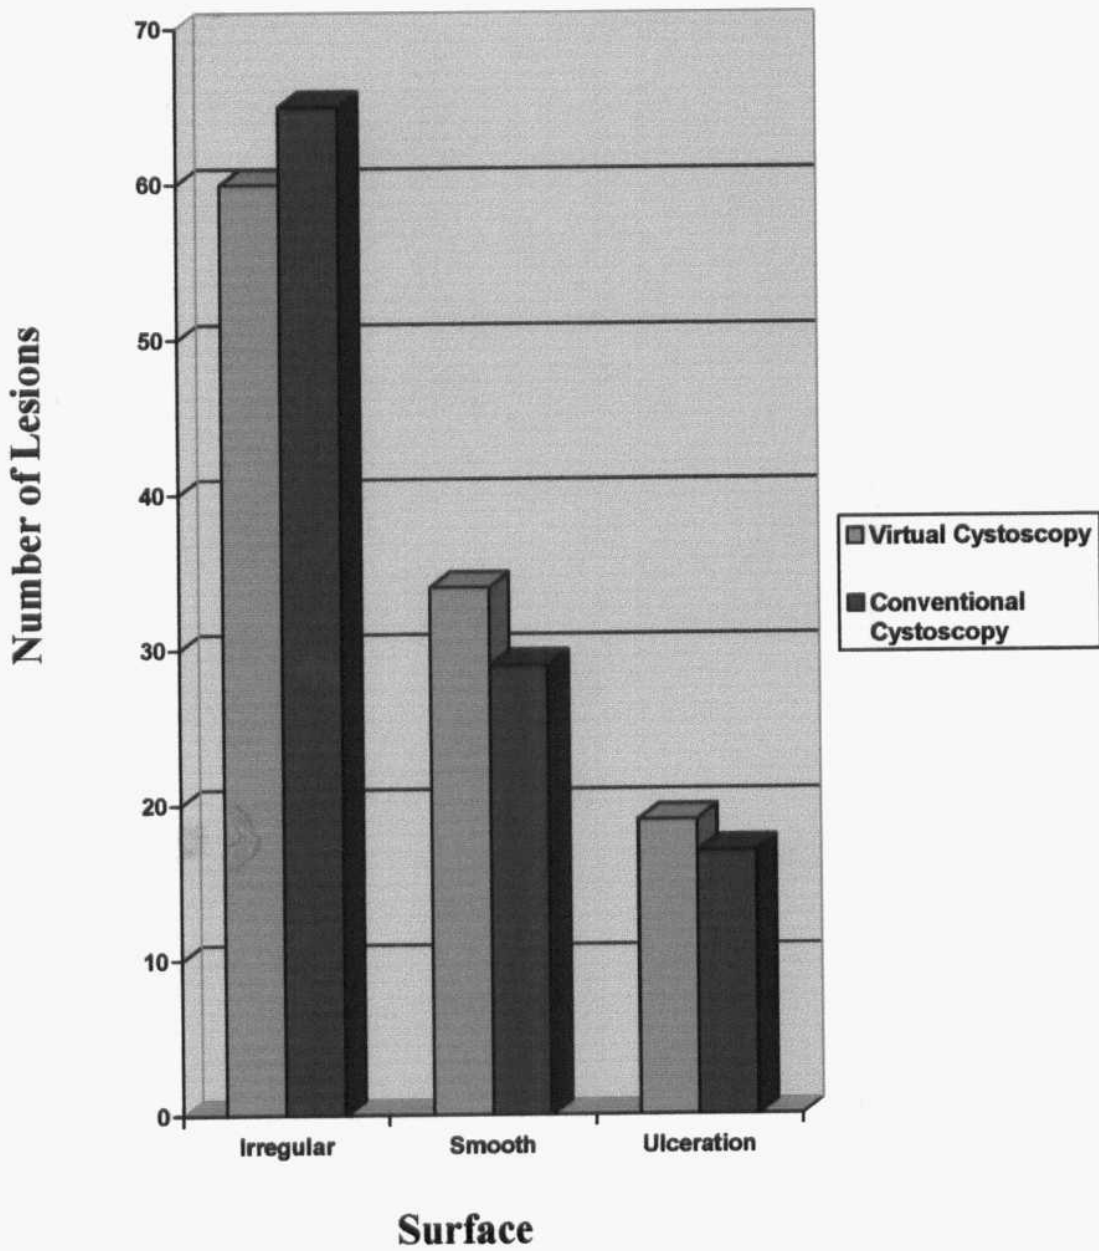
Comparison of lesion surface estimated by conventional and CT virtual cystoscopy images.
